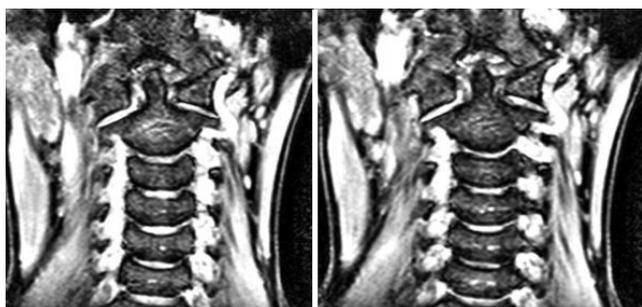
Magnetic resonance imaging showing the right sided alar ligament rupture.
